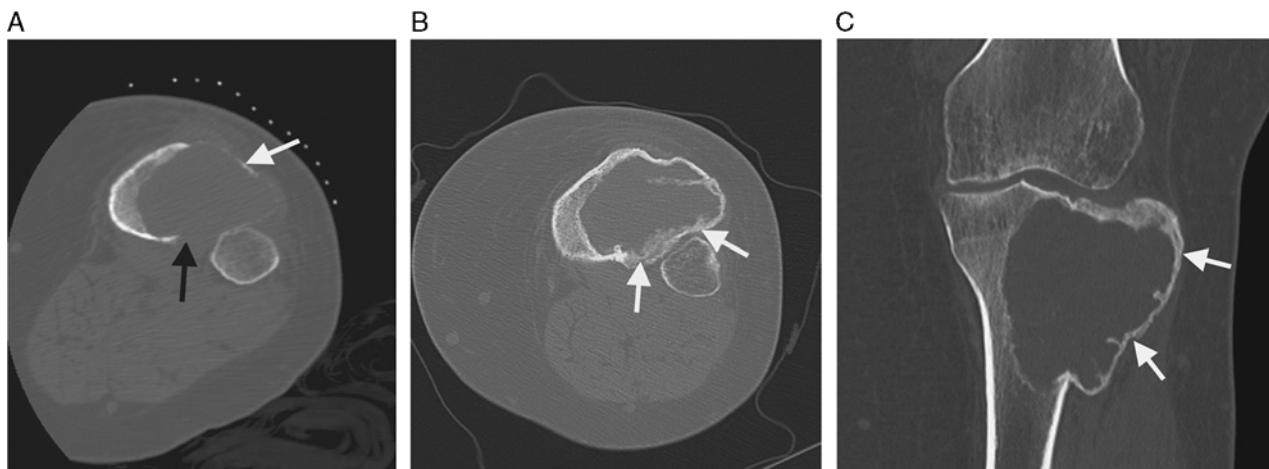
Radiologic features. CT of the proximal tibia before (A) and after (B and C) denosumab treatment. A, Axial CT image obtained as part of a biopsy shows a lytic lesion in the proximal tibia with thin sclerotic margin (white arrow) and areas of cortical break (black arrow). B and C, Axial and coronal images after denosumab therapy show interval bone formation (white arrows) involving predominately the peripheral aspects of the tumor.
